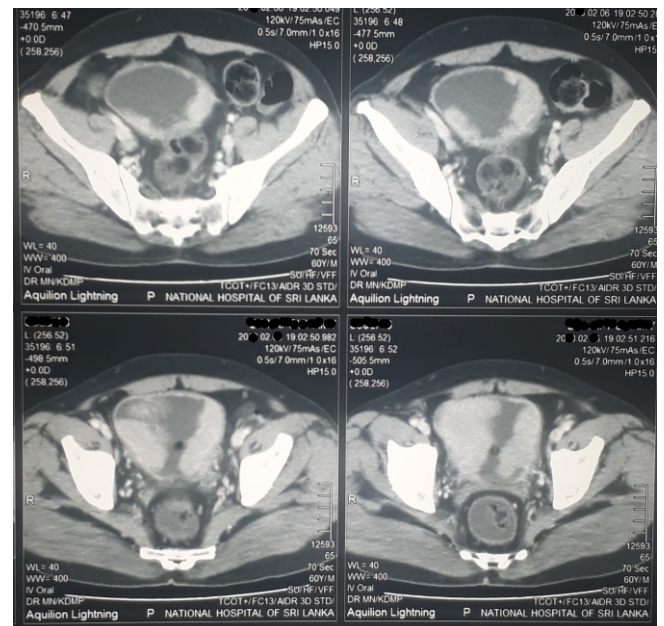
CT image of his bladder carcinoma
